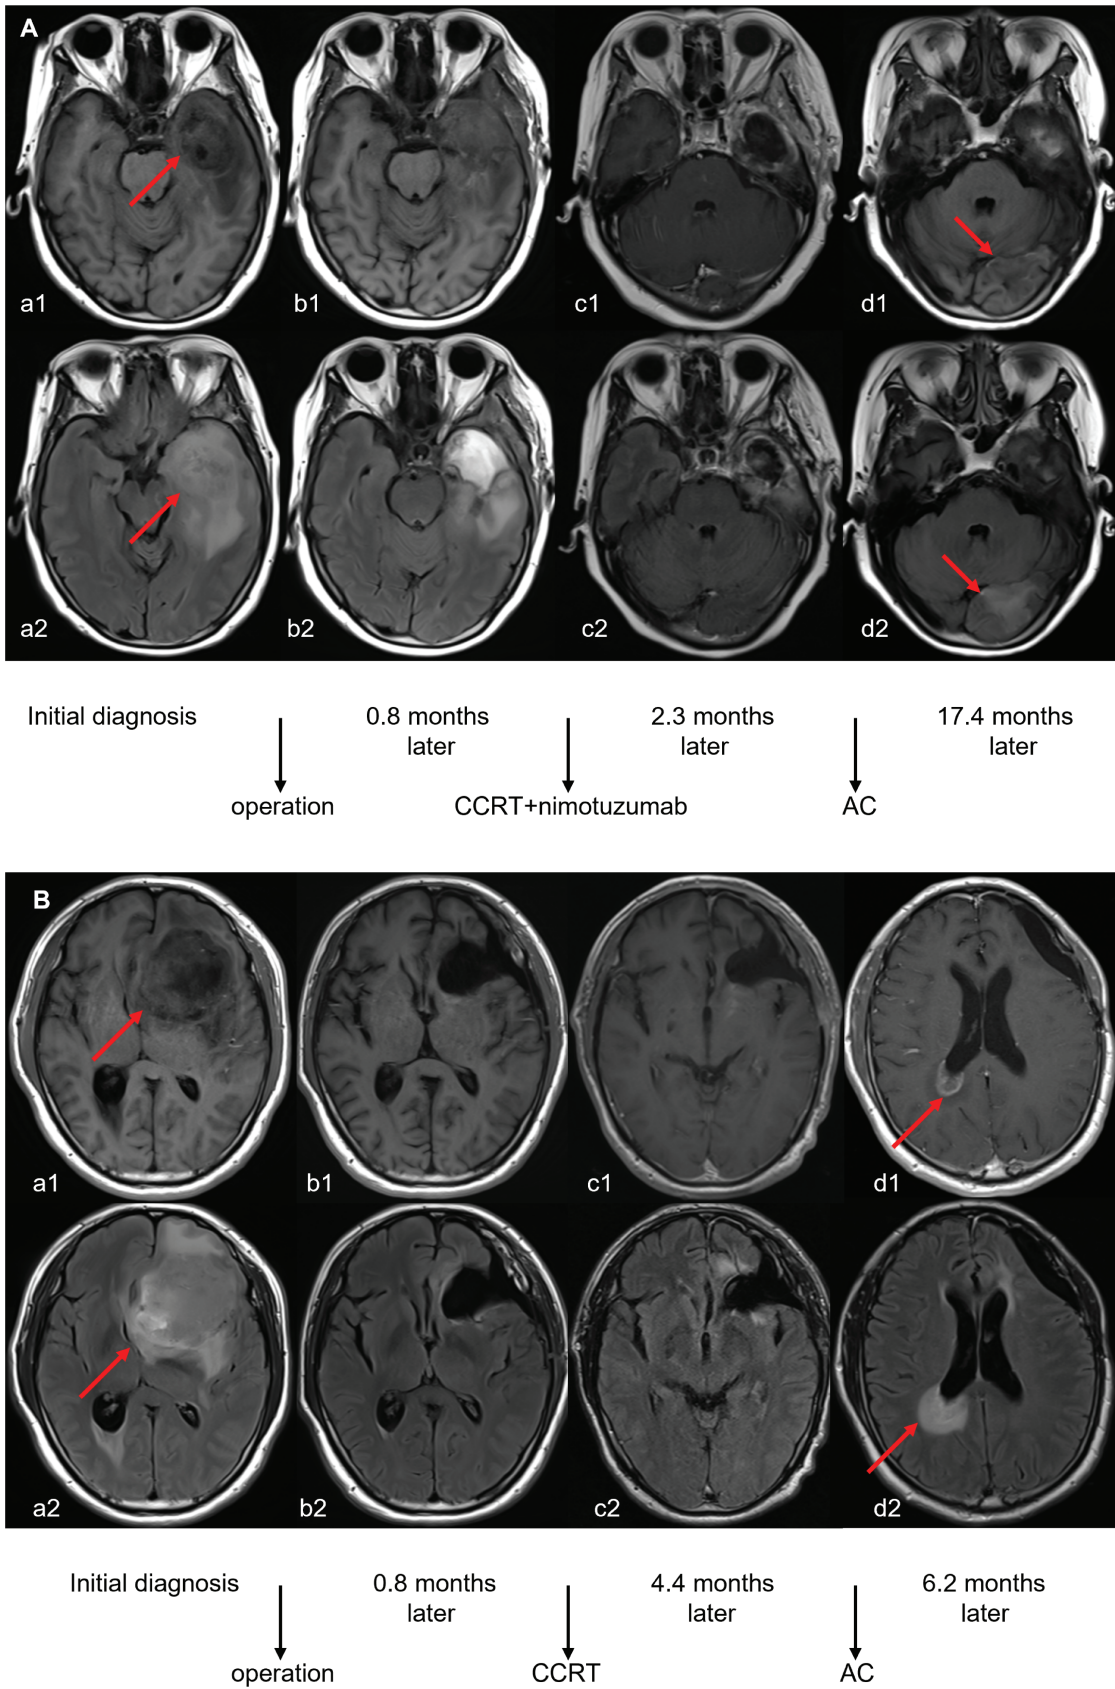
Magnetic resonance imaging (MRI) changes of glioblastoma (GBM) treated with nimotuzumab (A). MRI changes of GBM treated without nimotuzumab (B). Figures a-d represent pre-operation, post-operation, post-radiotherapy, and recurrence, respectively. (a1-d1) T1 enhanced MRI; (a2-d2) T2 fluid enhanced MRI. The arrow indicates the tumor area.
